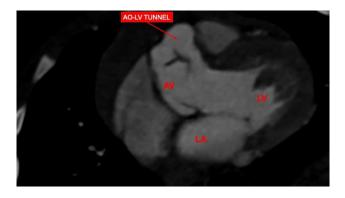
Contrast-enhanced computed tomography. This scan is particularly advantageous in providing an enhanced image of the tunnel. Abbreviations: AV, aortic valve; LV, left ventricle; LA, left atrium; AO, aortic valve.
